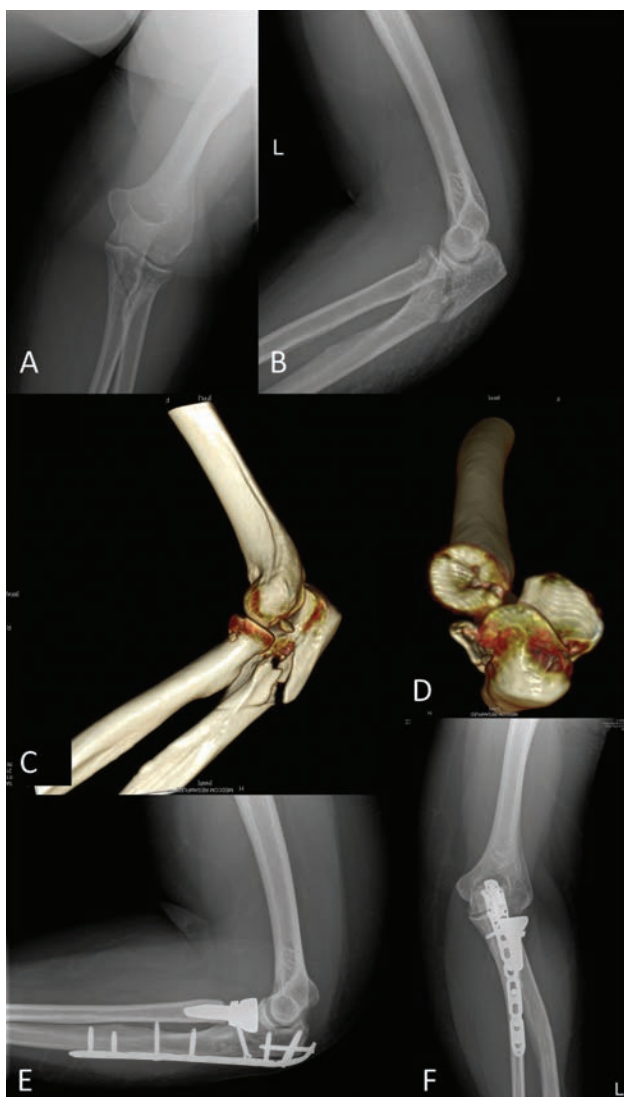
(A and B) radiographs and 3D CT of a transolecranon basal coronoid fracture with a comminuted radial head fracture. The patient is treated with a radial head replacement with the open reduction plate fixation of the proximal ulnar fracture.
